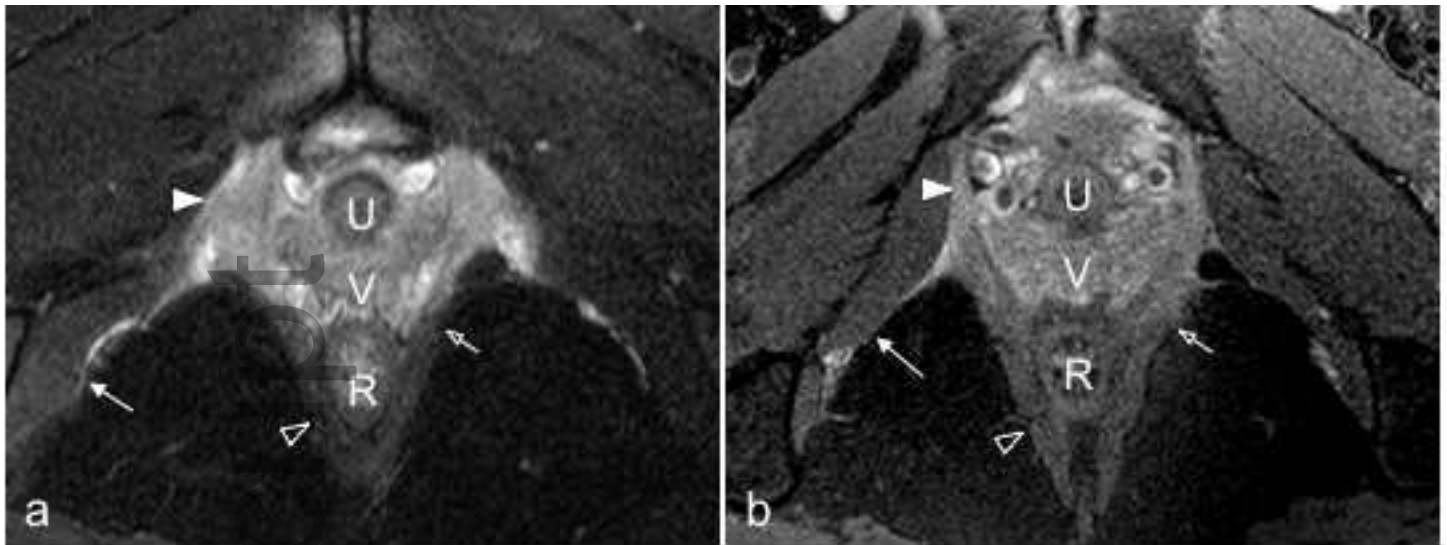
Fluid-sensitive axial MRI scans at the level where the pubovisceral (closed arrowhead) and the puborectal (open arrowhead) fibers diverge. Panels a and b exemplify two different subjects. Open arrow indicates transition between edema in the pubococcygeal and lack of edema in the puborectal muscles. Obturator internus muscle is indicated (closed arrow). (U) Urethra; (V) Vagina; (R) Rectum.
